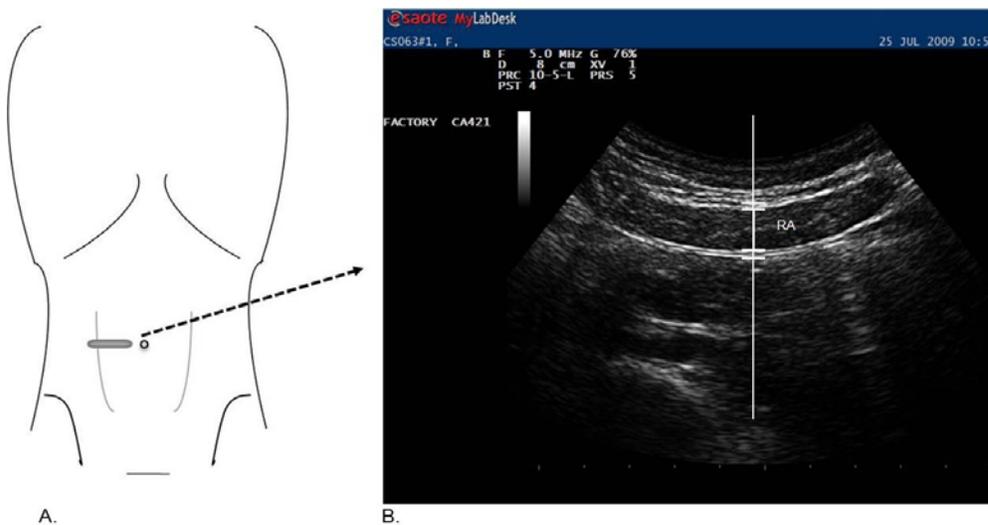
A. Rectus abdominis (RA) imaging site. B. Transverse ultrasound image of the right rectus abdominis (RA) showing a vertical reference line along which the thickness of the RA muscle and associated connective tissue planes were made.
